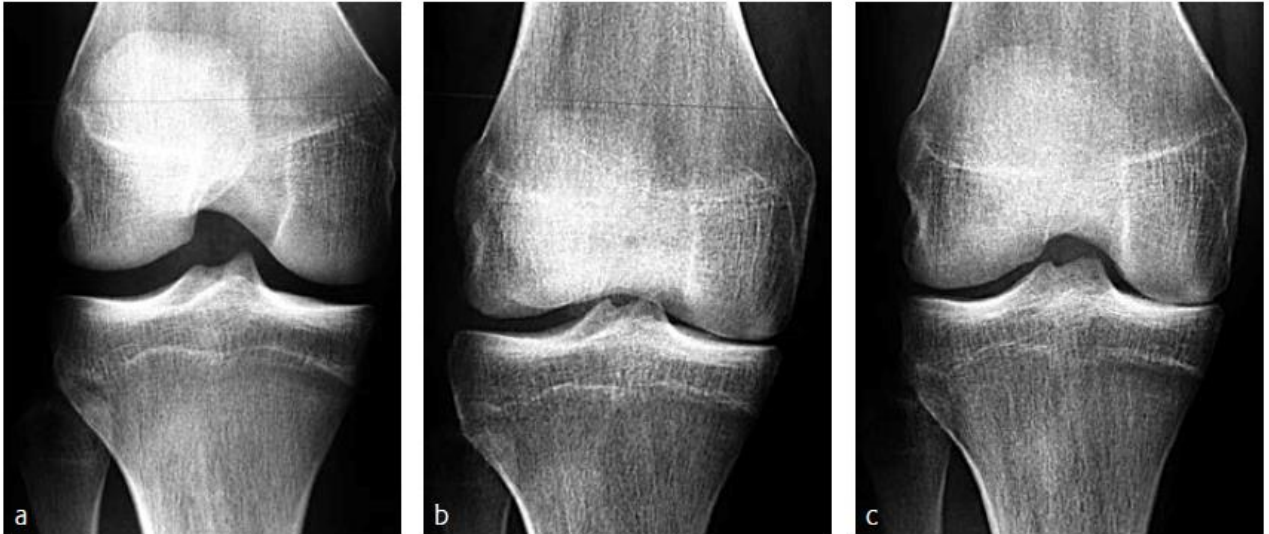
Rapid joint destruction in a 21-year-old athlete after mistreated septic arthritis with methicillin-susceptible *Staphylococcus aureus* (3 months between first and last x-rays).
